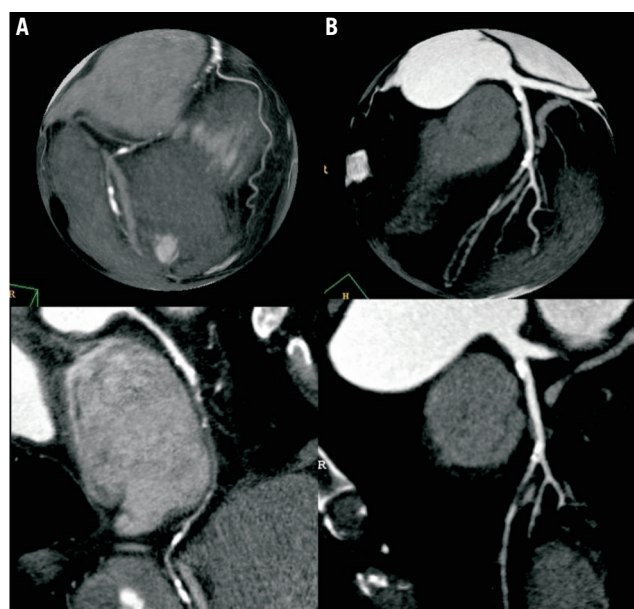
Preprocedural computed tomography coronary angiography of chronic total occlusions might aid discrimination between patients with a low (small reference diameter, very long lesion, calcification and side-branch at entry, diffusely diseased distal coronary bed) and high (short, non-calcified lesion, without side-branch at entry, tortuosity or angulation and a non-significant calcification 9 mm proximal) likelihood of success.
